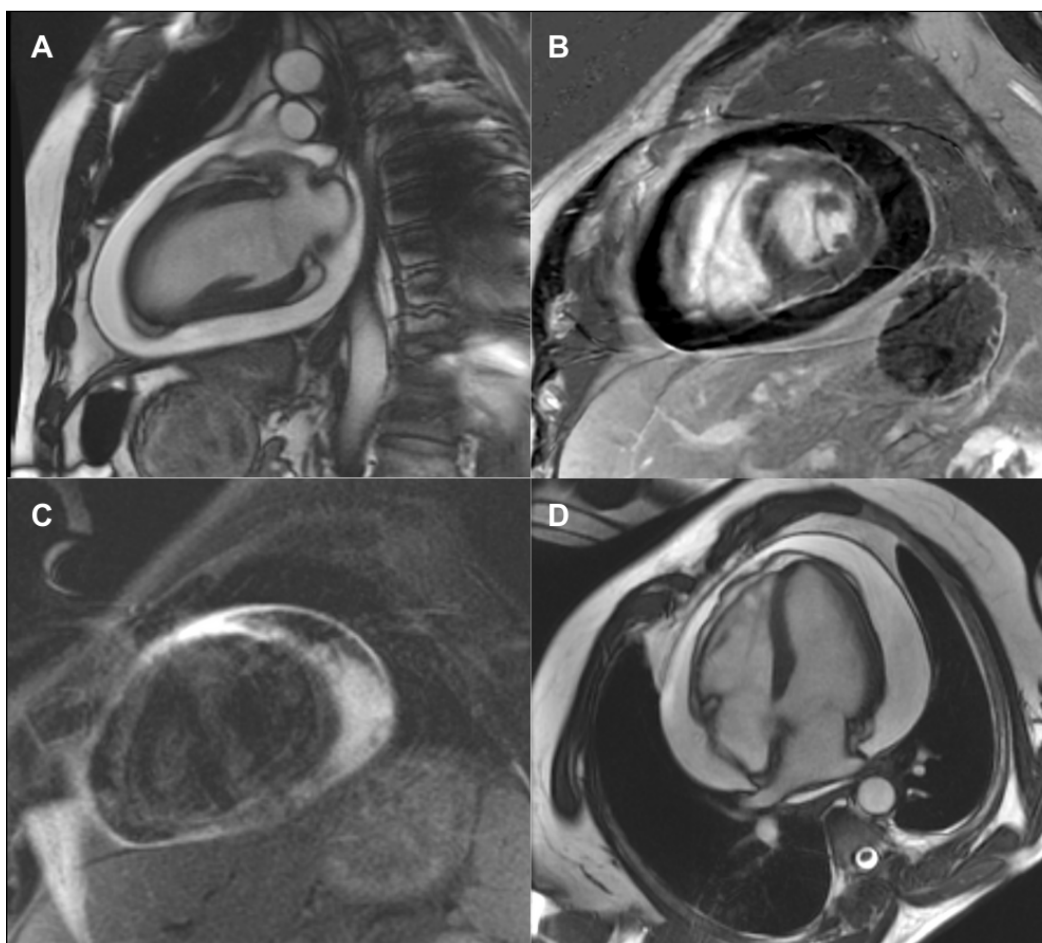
Cardiac magnetic resonance (CMR) assessment of pericardial effusion. (A) A cine still frame of a two-chamber view, and (D) four-chamber view shows a large circumferential pericardial effusion of simple fluid. (B) Late gadolinium enhancement imaging on CMR shows a large circumferential pericardial effusion with mild pericardial enhancement, suggestive of fibrosis. (C) T2-weighted imaging shows increased signal in the visceral and parietal pericardium in suggestive of active pericardial edema.
